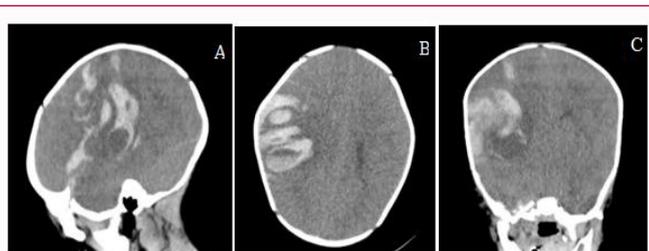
CT-Scan brain without contrast showing massive right front parietal intracerebral hemorrhage with mass effect resulting in contra lateral midline shift with the possibility of impending herniation. A) Sagittal view, B) Axial view, C) Coronal View.
